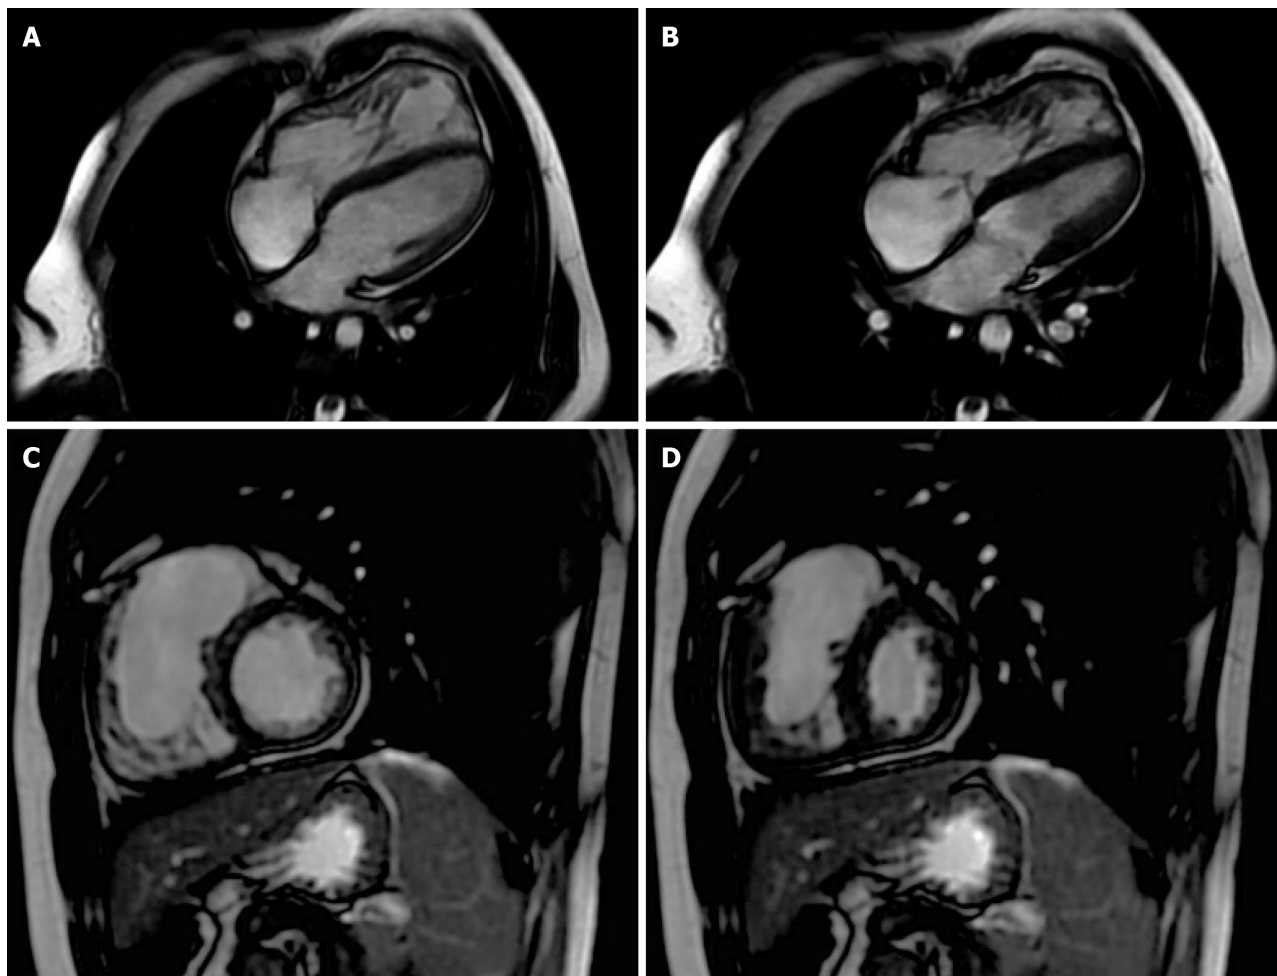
Cardiac magnetic resonance imaging cine sequences (June 2022). A: Four chamber view: Enlargement of the right ventricle and increased right ventricle trabeculation; B: Systolic image showing tricuspid valve regurgitation; C: Short axis in diastole; D: Short axis in systole. No saccular lesion of the right ventricle was observed in this study.
